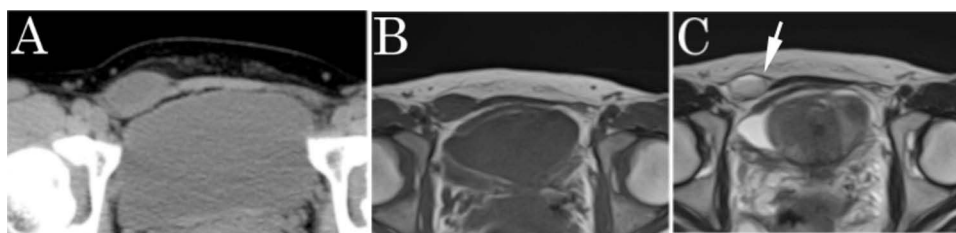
A 44-year-old woman with right inguinal endometriosis with fluid-fluid level feature (Case 2). The preoperative computed tomography showed a 3-cm well-defined mass over the caudal end of the right rectus abdominis muscle (A). Magnetic resonance imaging showed isointense mass lesion compared with muscle on T1-weighted images (B). On T2-weighted images, the tumor was hyperintense with a single fluid-fluid level feature (C; arrow).
